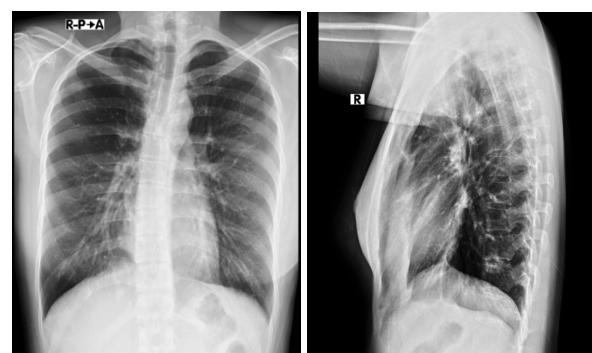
Chest radiograph on admission (September 12th, 2025)
